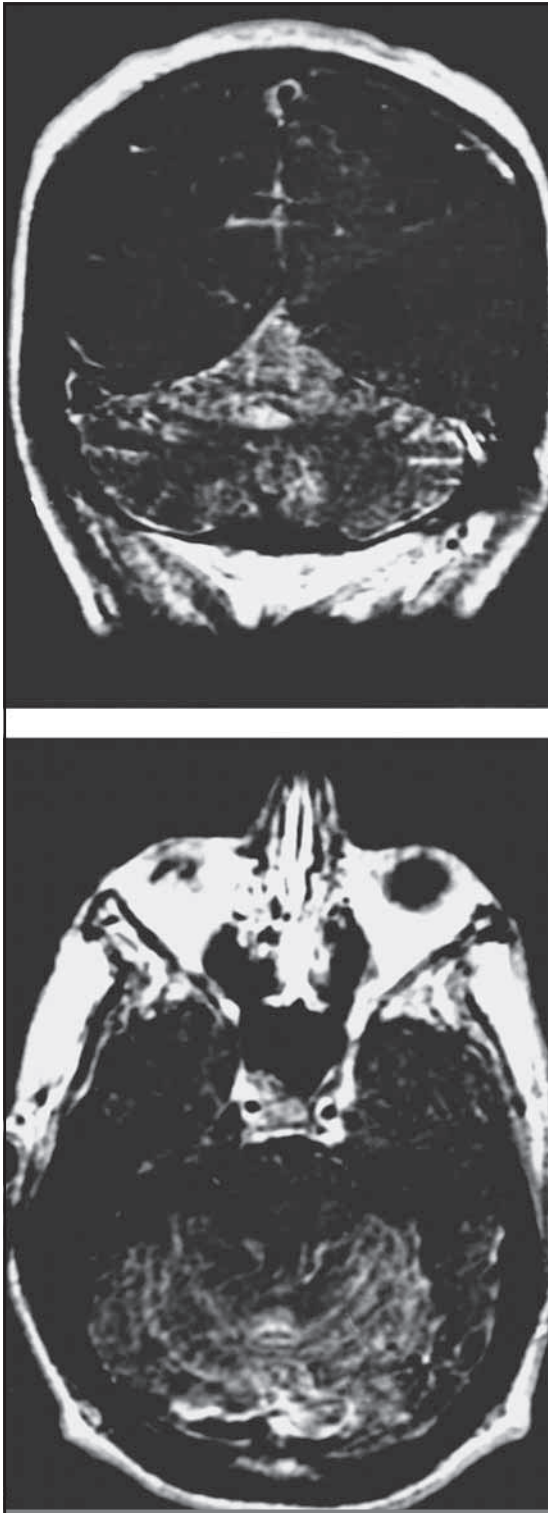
MRI scan that demonstrated diffuse meningeal enhancement, most prominent in the posterior fossa in a patient with immune reconstitution syndrome in the setting of treated cryptococcal meningitis. The patient presented with fevers, headache and loss of vision due to a marked increase in intracranial pressure. (a) axial post-contrast T1-weighted image; (b) coronal post-contrast T1-weighted image. Reprinted with permission from reference 3.
